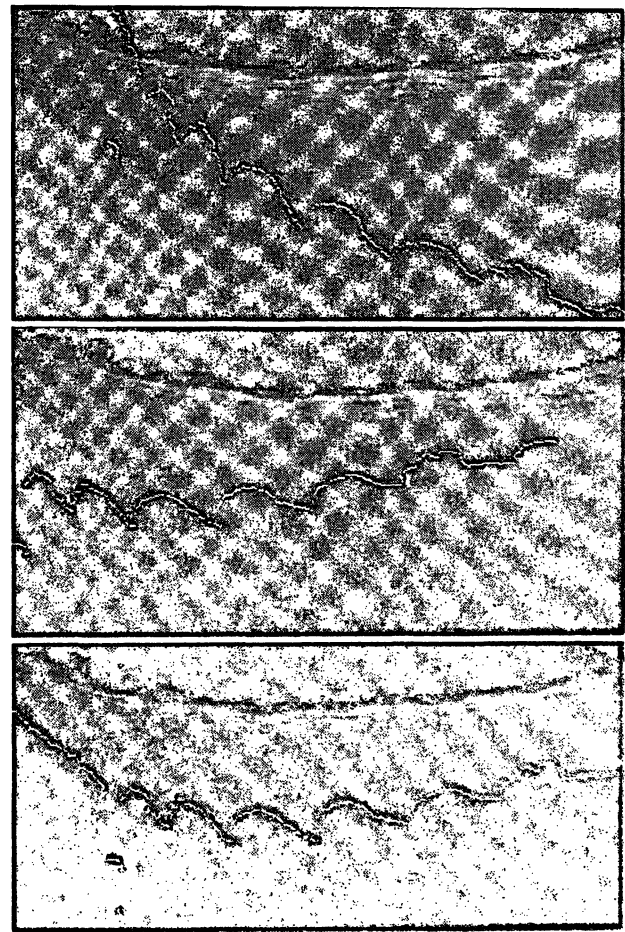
Surface points, extracted from the CT-data, projected into the ultrasound data. The upper and middle images show this before registration, the surface was rotated about 30 degree, and shifted 40 mm, the lower image is after registration.
